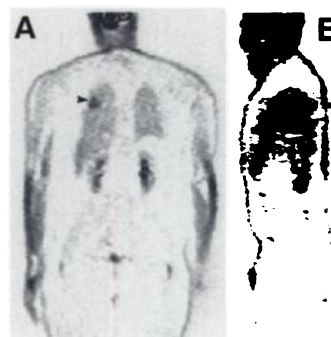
Uptake of FDG in a patient who developed a *P. aeruginosa* infection of the right lung (indicated by the arrowheads), coronal (A) and sagittal (B) images.
